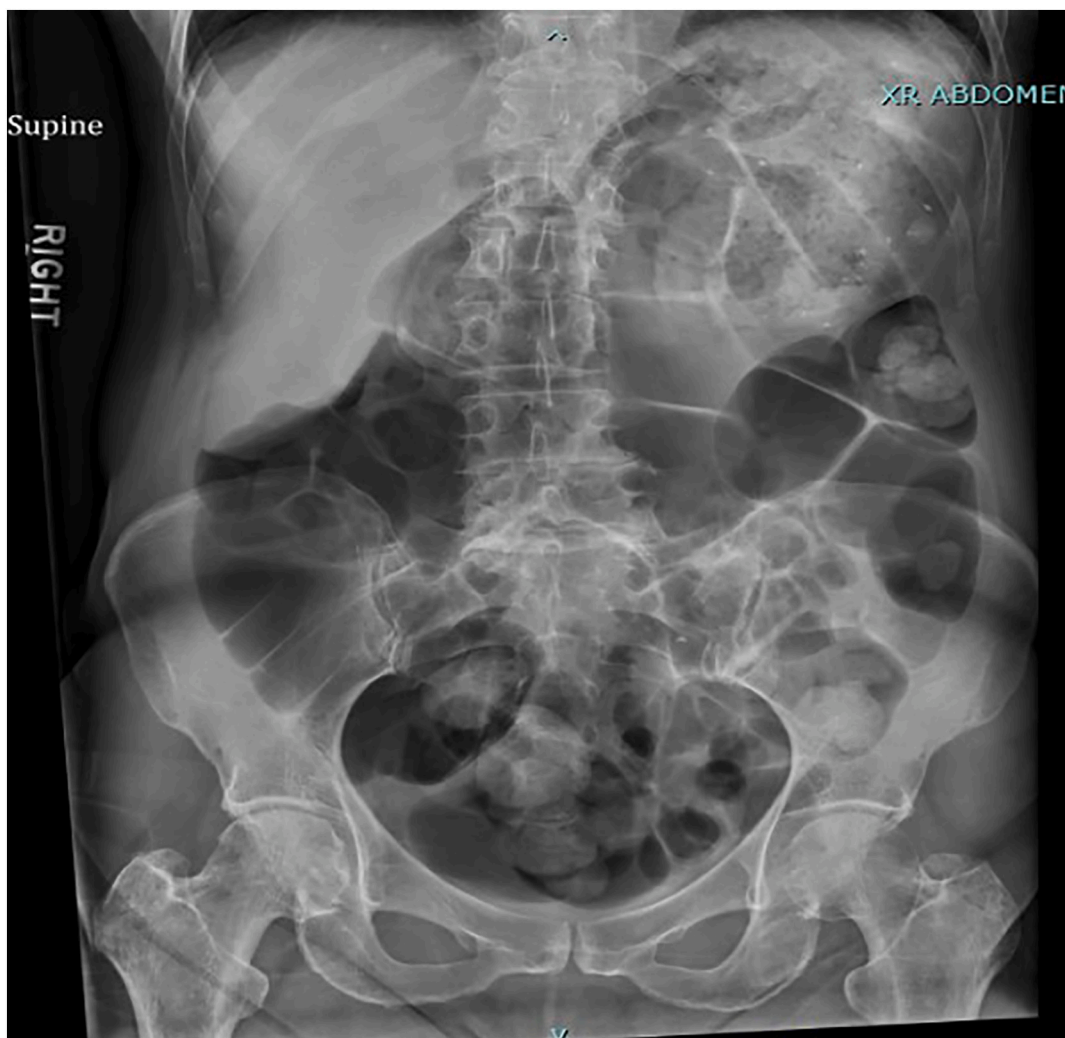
Abdominal X-ray with diffuse colonic dilation and a moderate amount of retained fecal matter
